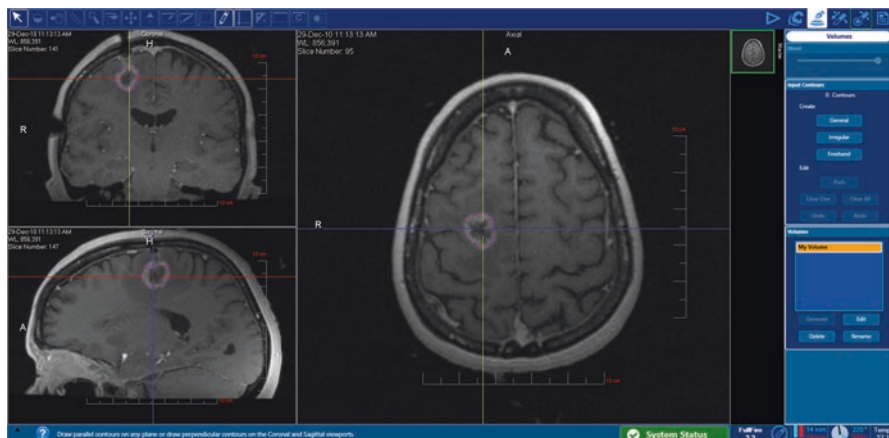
Intraoperative use of MRI to define tumor contour (pink line)
